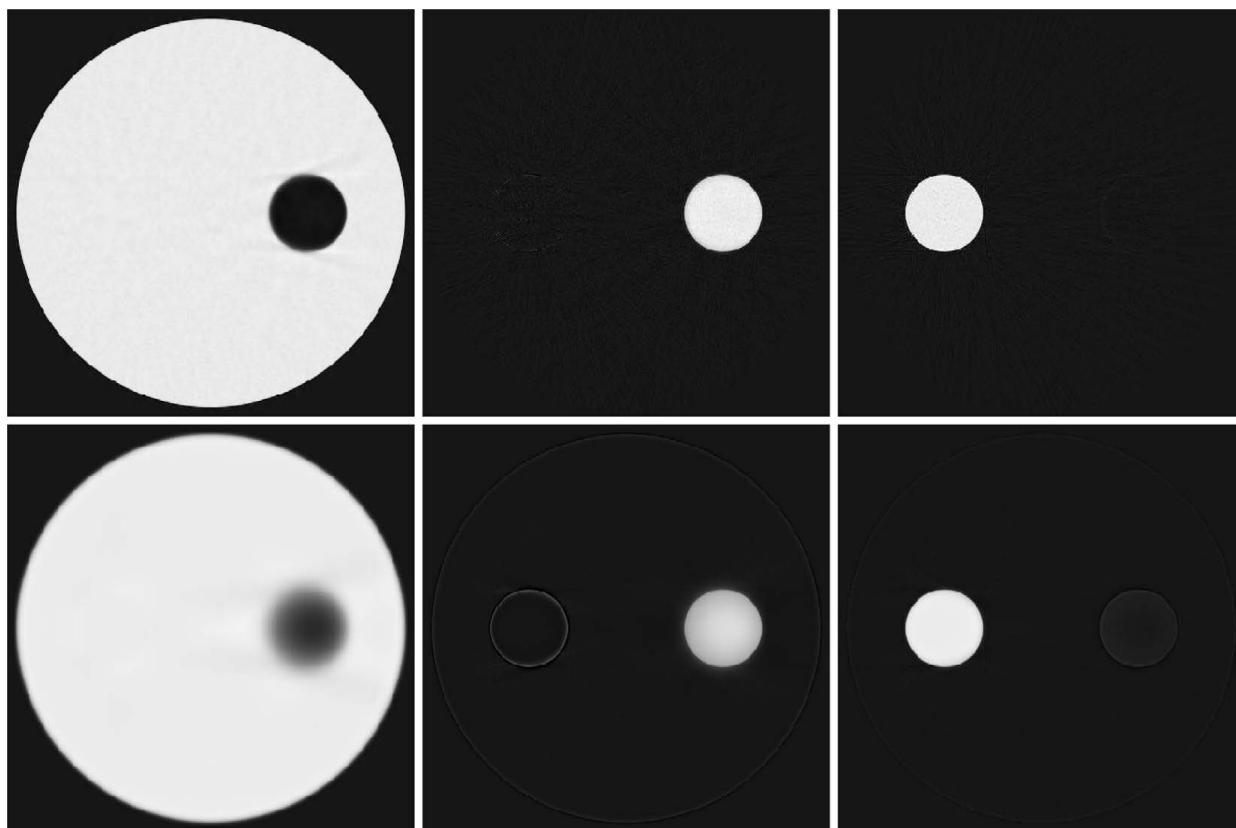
Effect of regularization on one-step reconstruction [40] from the same data as in [Figure 19.6](#). The regularizer is Green’s approximation of TV [20] on each material-specific CT map. The number of iterations was increased to 1000 to reach (visual) convergence. The regularization weights (one per material-specific CT map) have been first chosen to be maximum without visible cross-talk (top) and 100 times larger each (bottom). The grayscale is the same as in [Figure 19.6](#).
